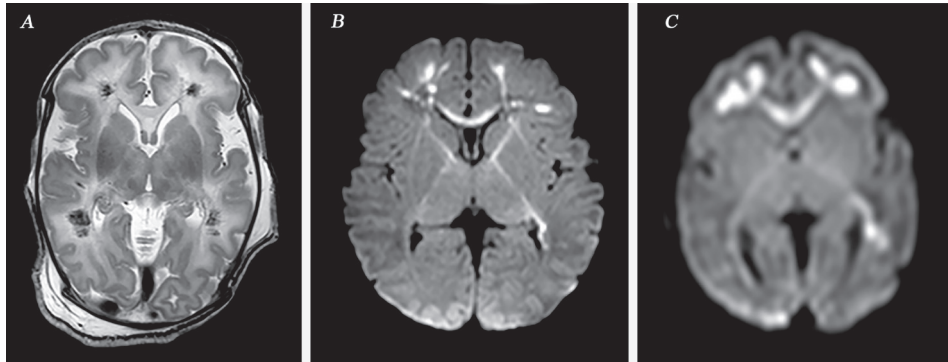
MRI, axial plane in an infant with EV (A), HPeV (B) and HSV (C) infection. In A, a T2 sequence is used, in B and C, DWI. The distribution of abnormalities in the white matter is comparable. In the infant with EV infection there is a hemorrhagic component. In the infants with HPeV and HSV infection, involvement of the corpus callosum and optic radiation (left side) is seen as well and in the infant with HPeV infection the internal capsule shows also restricted diffusion.
